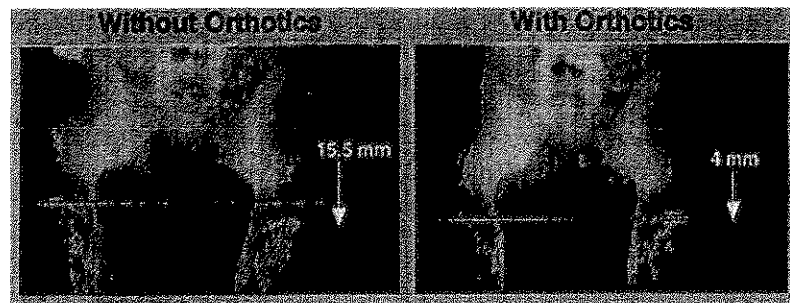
Before and after X-rays (A) with orthotics and (B) without orthotics.
